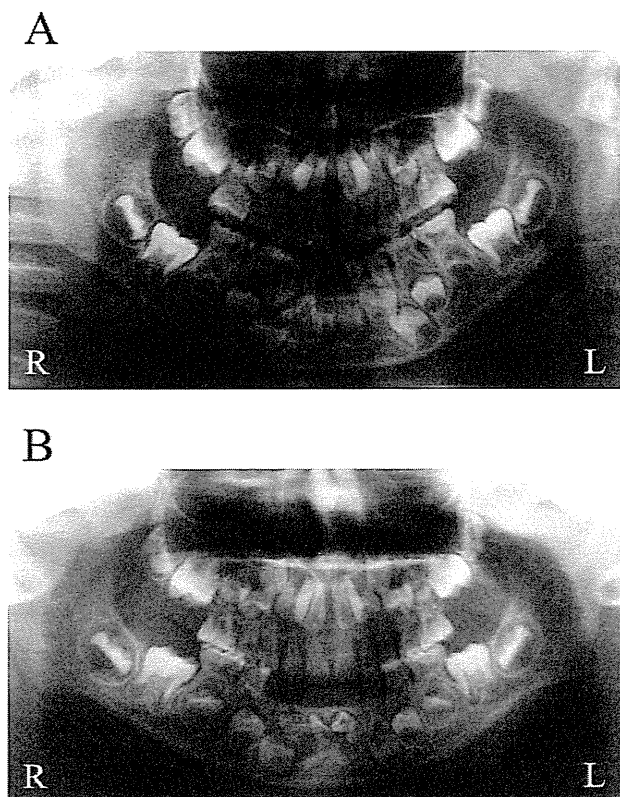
Orthopantomograph of fraternal twins obtained at 6 years 3 months of age
